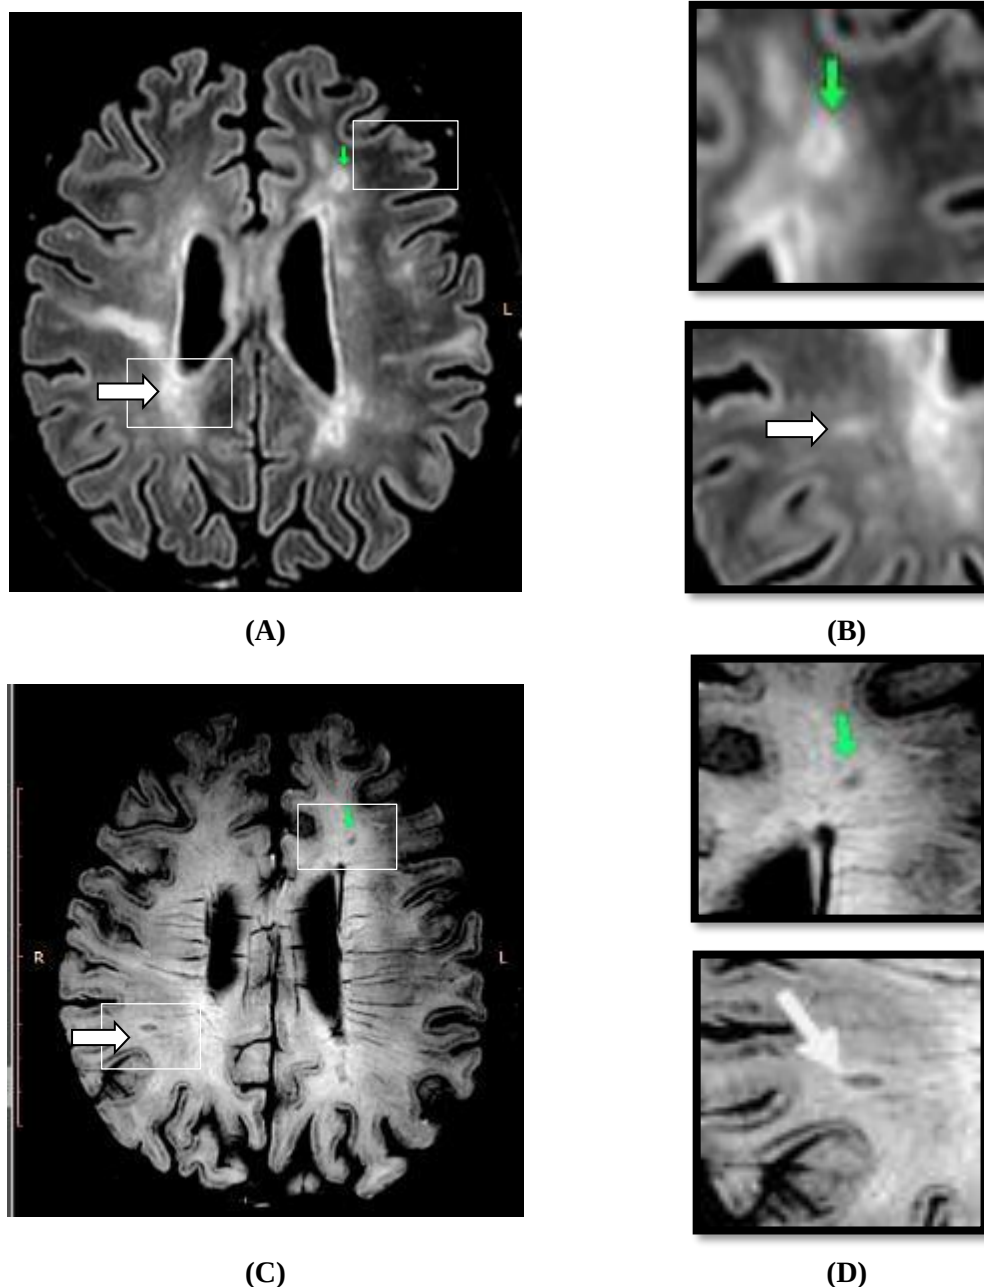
A) An axial periventricular lesion (green arrow) demonstrated the central vein sign on 3D FLAIR. B) Central vein sign in an axial 3D FLAIR periventricular lesion. C) A periventricular lesion demonstrating the central vein sign on SWI, which is much higher than that on 3D FLAIR. D) A FLAIR bright lesion seen on 3D FLAIR, which failed to show the central vein that was clearly visualized on SWI.
